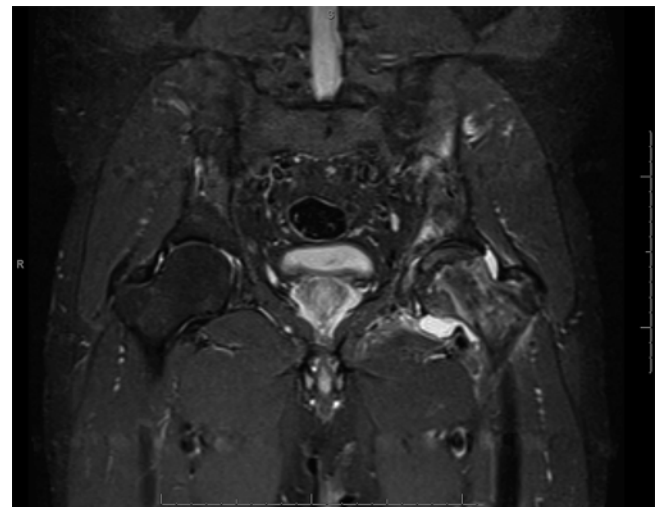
MRI STIR sequence with contrast showing ON with subchondral fracture in the pre-collapse stage. Note the unilateral synovial effusion in the left symptomatic hip and absence of effusion in the right asymptomatic hip
